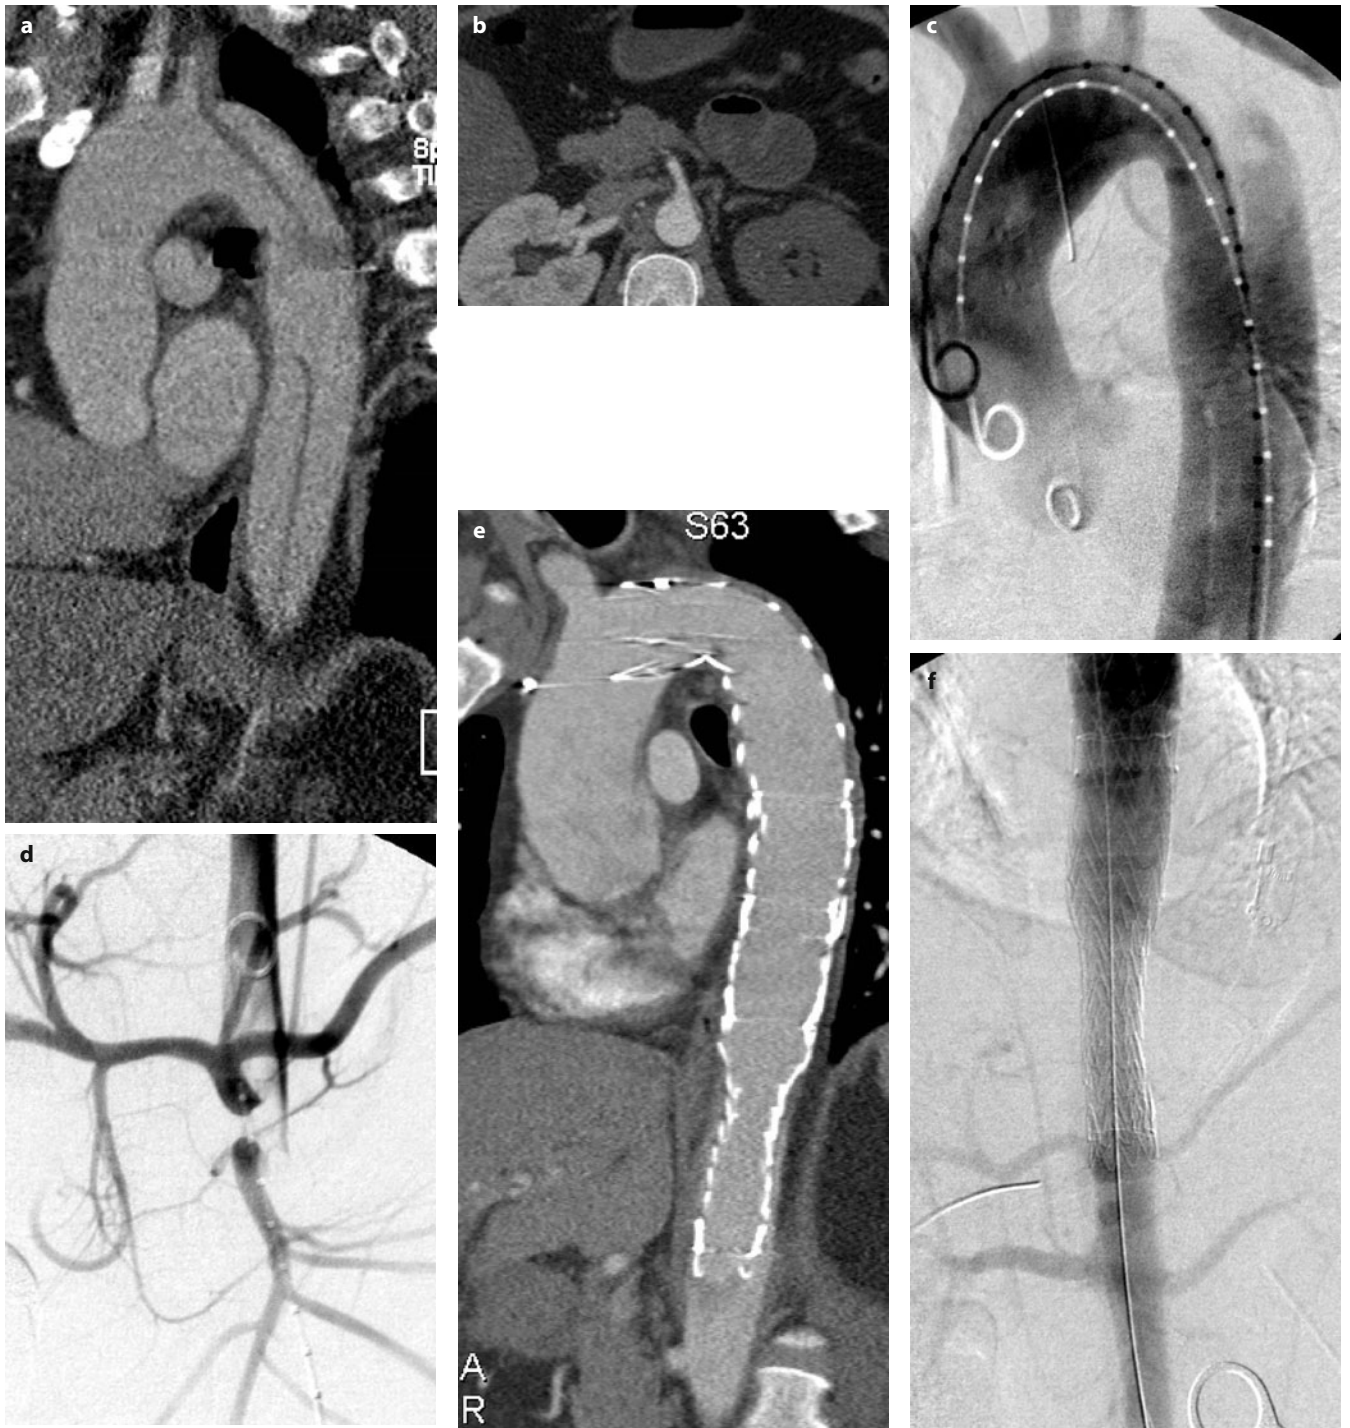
a-f. Complicated Stanford type B aortic dissection with renal malperfusion. a Computed tomography (CT) demonstrating primary entry tear of type B aortic dissection. b CT demonstrating compression of true lumen of the aorta with left renal ischemia. c Aortic angiogram showing true and false lumen of type B dissection. d Aortography showing compression of true lumen with malperfusion of the renal arteries (“floating visceral sign”). e CT after stent-graft implantation and closure of primary entry tear with false lumen collapse. f Aortography post stent-graft implantation demonstrating spontaneous revascularization of visceral arteries
